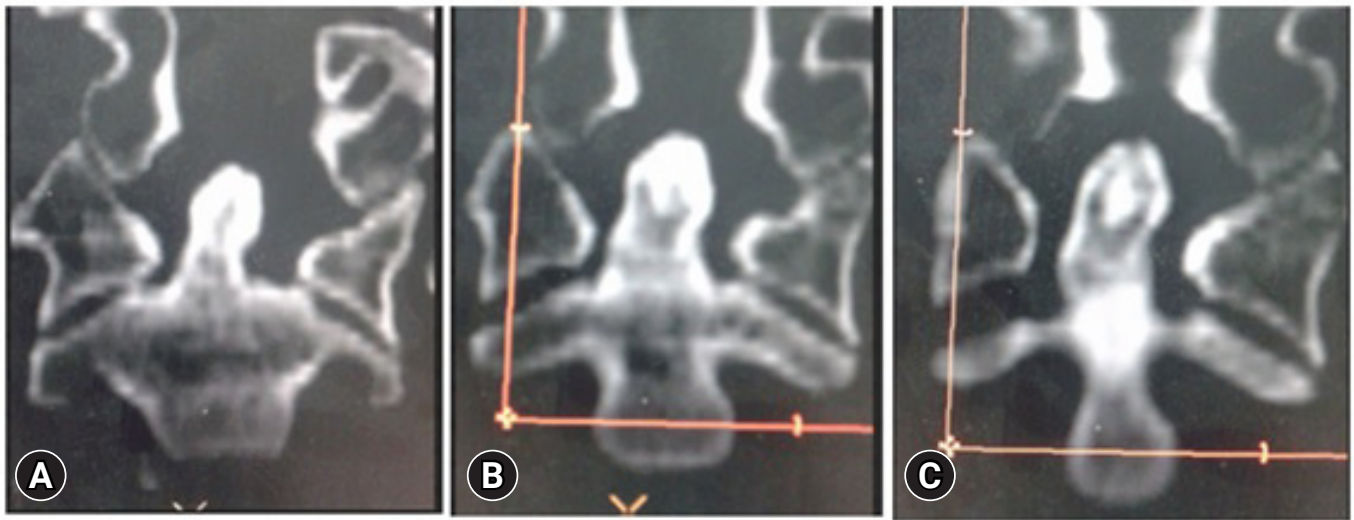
(A–C) A coronal reformatted computed tomography scan of the cervical spine taken 3 months after treatment by external fixation. (A–C) Different sections show complete healing of the previously described complete irregular fracture at the base of odontoid process (C2), with minimal tilt of its vertical axis slightly to the left.
